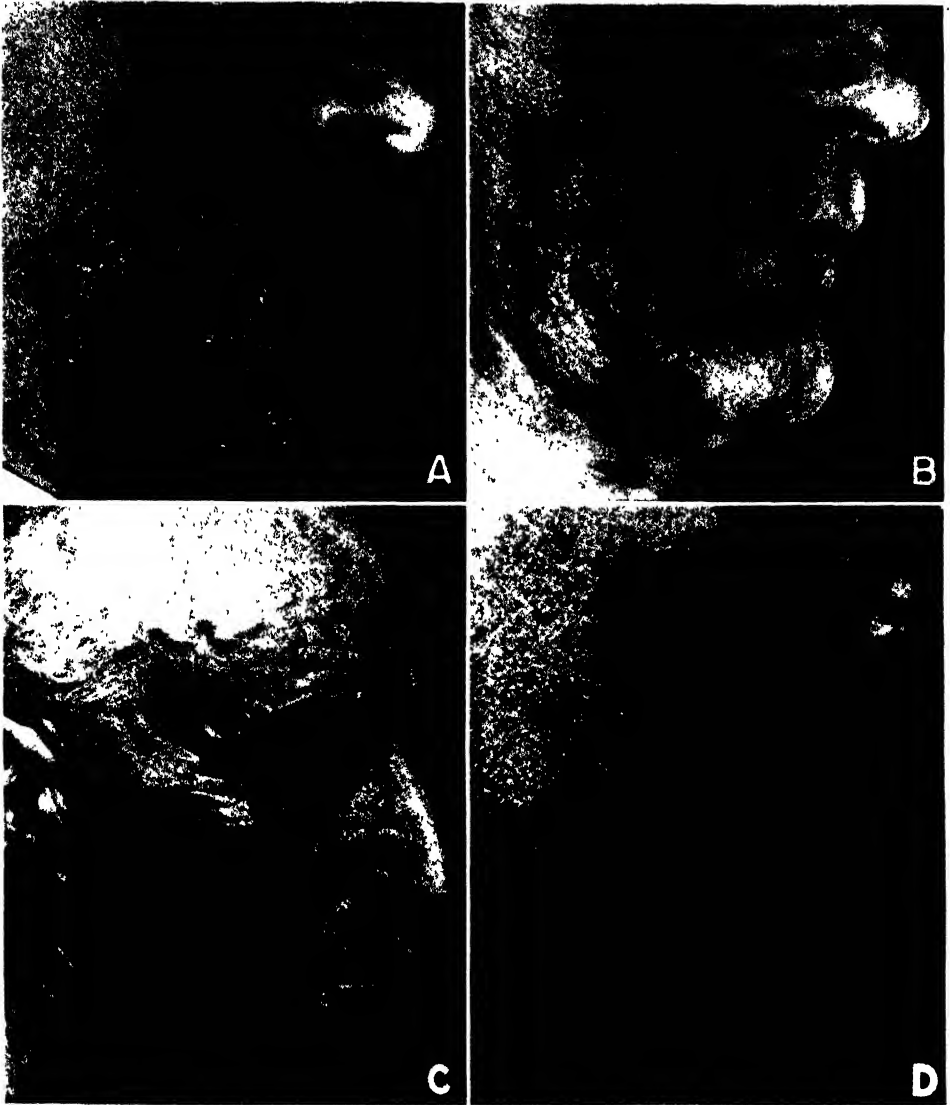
Tinea barbae. *A*, *T. gypseum* infection before treatment. *B*, same patient following x-ray therapy and manual depilation. (Courtesy of M. Silverberg.) *C*, small follicular pustules due to *T. purpureum*. *D*, *M. lanosum* infection in a delicatessen worker.
